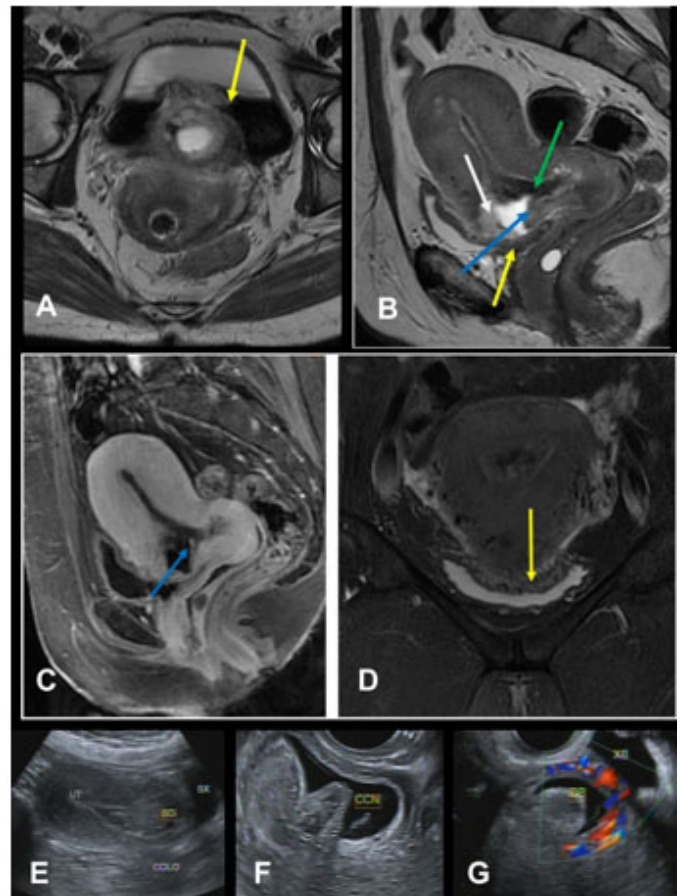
(A) Axial T2, (B) Sagittal T2, (C) Sagittal T1 FAT SAT—post-gadolinium, (D) Coronal T2 FAT SAT. Ectopic pregnancy in the type II cesarean scar (exogenic) with trophoblast/placenta percreta signs (yellow arrows). Anteverted uterus with gestational sac (blue arrows) transmurally located in the anterior isthmic region in the cesarean scar, with extension of the trophoblast/placenta (white arrow) in addition to the uterine serosa without cleavage plane with the posteroinferior wall of the bladder (yellow arrows). Gestational sac (blue arrows) with thickened semi-circumferential parietal tissue compatible with trophoblast/placenta showing contrast enhancement. Slight distention of the uterine and cervical cavities due to hypointense content on T2 consistent with recent bleeding (green arrow). (E and F) An ultrasound study of the patient showing an anteverted uterus, in a globose shape, containing a single gestational sac (GS), located in an isthmic topography, in an exophytic position, over the topography of a scar from a previous cesarean section. It was not possible to identify the trophoblasto-myometrial interface properly. (G) The presence of intense vascularization on the Doppler study in the trophoblast/placenta is also noted, which may correspond to placental accreta.
